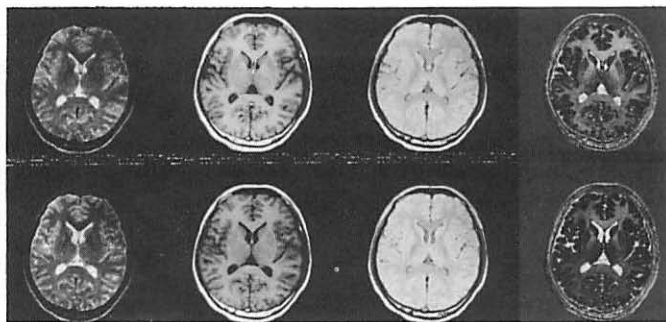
A nonlinear combination of three-channel MR images (T2-weighted images, T1-weighted images, PD-weighted images and nonlinear combined images).
